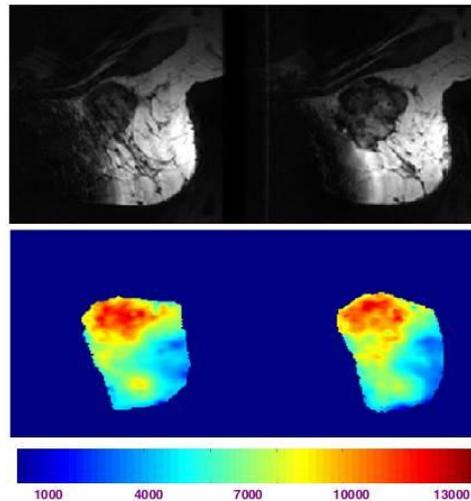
Representative MRE study of a breast lesion. (Top) the MR images of a the lesion before and after chemotherapy. (Bottom) Corresponding quantitative elasticity maps based on MRE of the same areas of interest, at both time points. A reduction of the highest values of stiffness is noted after chemotherapy [16].
